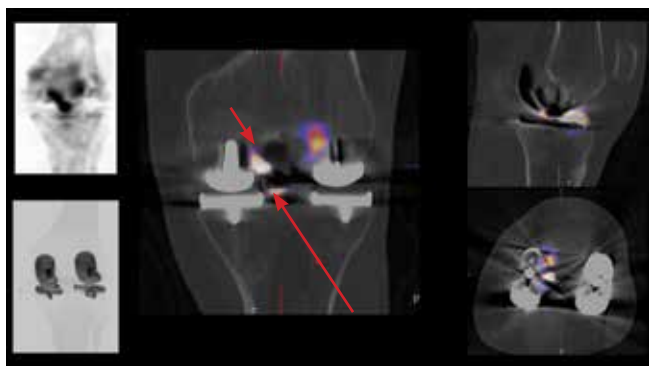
xSPECT Bone maximum intensity projection (MIP) images (upper left corner) show focally increased tracer uptake in the tibial intercondylar eminence and in the lateral margin of the medial femoral condyle. xSPECT Bone/CT fusion shows increased uptake in the medial tubercle of the intercondylar eminence of the left tibia located adjacent to the medial tibial plate of the hemiarthroplasty prosthesis (long red arrow), which suggests impingement of the medial intercondylar eminence with the edge of the tibial component in the prosthesis. The lateral edge of the medial femoral condyle shows focally increased uptake predominantly in the anterior aspect (short red arrow), which suggests impingement of the edge of the femoral component of the medial hemiarthroplasty prosthesis with an osteophyte in the adjacent condylar bone (which demonstrates the highest uptake and is probably the main site of the knee pain).
